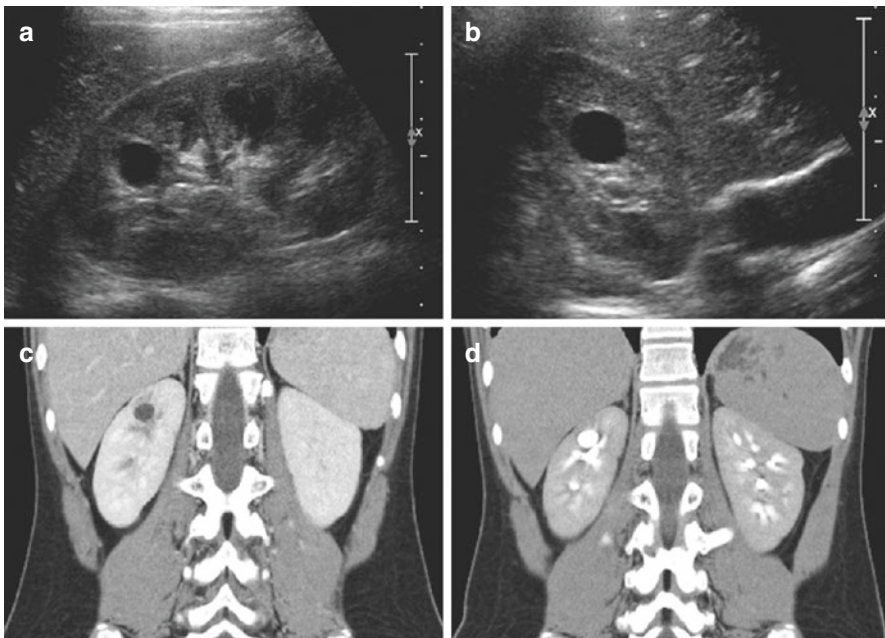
Calyceal diverticulum visualized on ultrasound—longitudinal (a) and transverse (b)—and CT scan with contrast—nephrogram (c) and excretory phase (d). Reproduced with permission from Lee [93]
